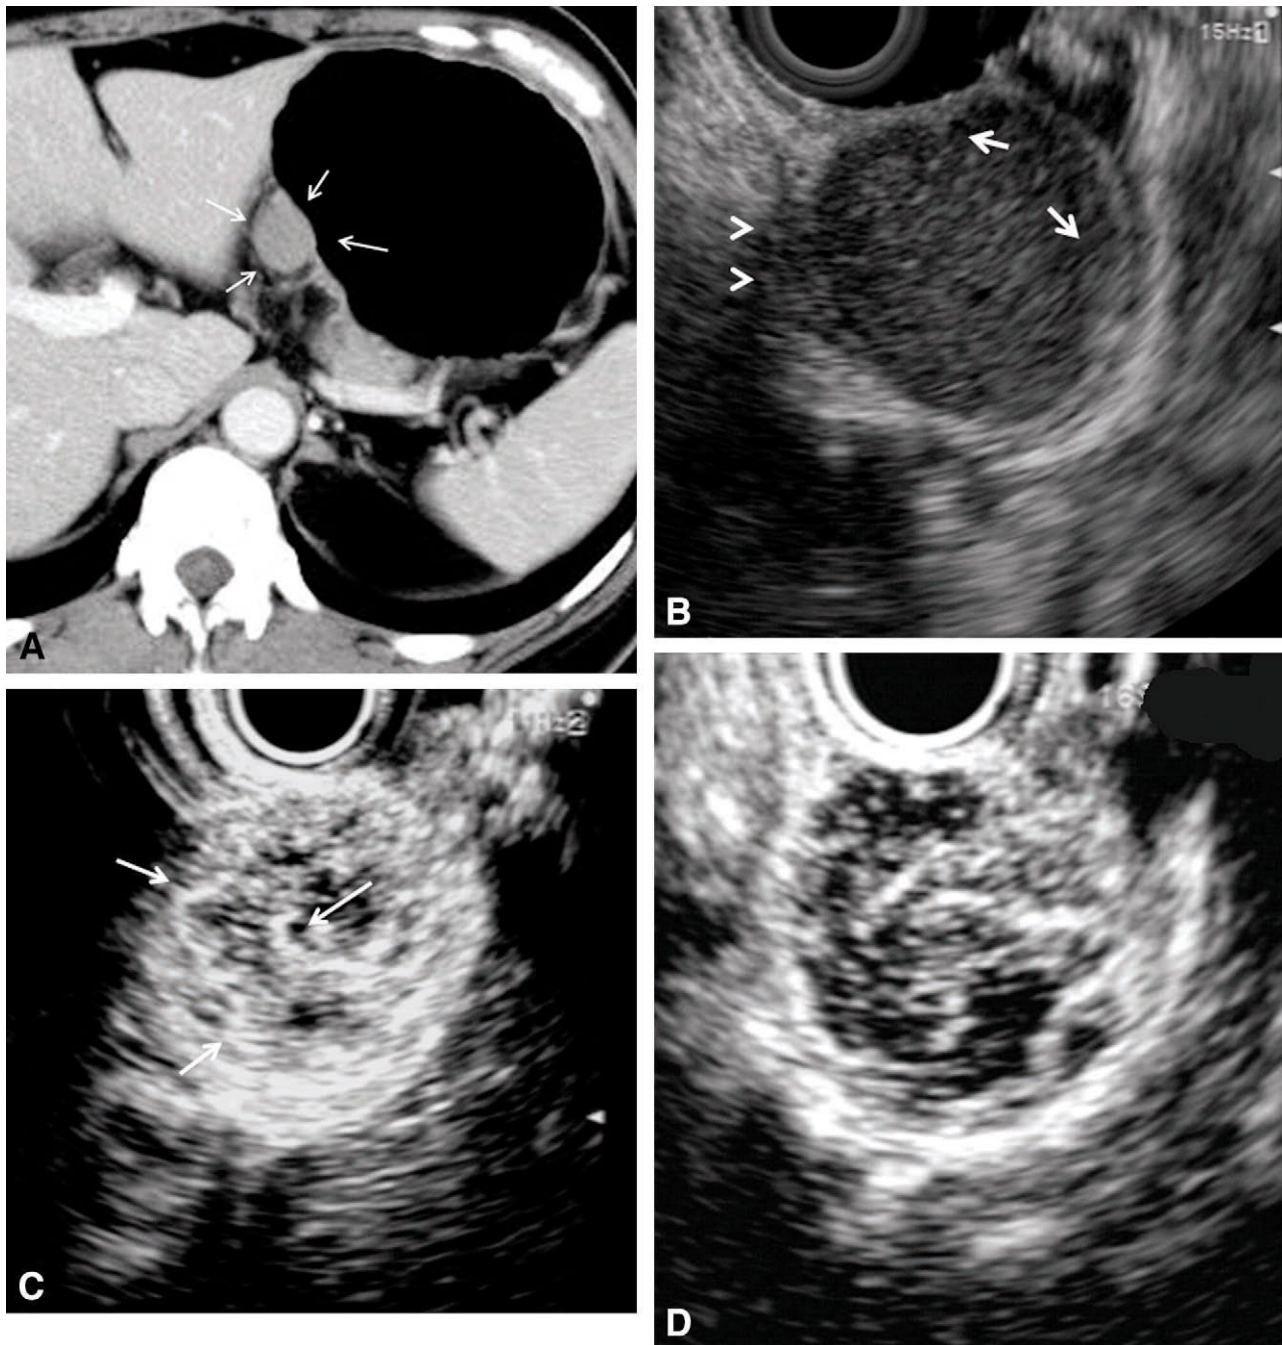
Typical type II tumor lesion: high-grade malignancy GIST of the stomach in a 41-year-old man. A, CE-CT showing homogeneous enhancement of a 24-mm-diameter tumor (*arrows*). Intratumoral vessels are not seen. B, EUS showing the homogenous appearance, incomplete tumor lobulation (*arrows*), and local invasion (*arrowheads*) of a 22-mm-diameter gastric tumor. C, Vessel image of CEH-EUS showing irregular vessels flowing from the periphery to the center of the tumor (*arrows*). D, Perfusion of CEH-EUS showing heterogeneous appearance within the tumor.
